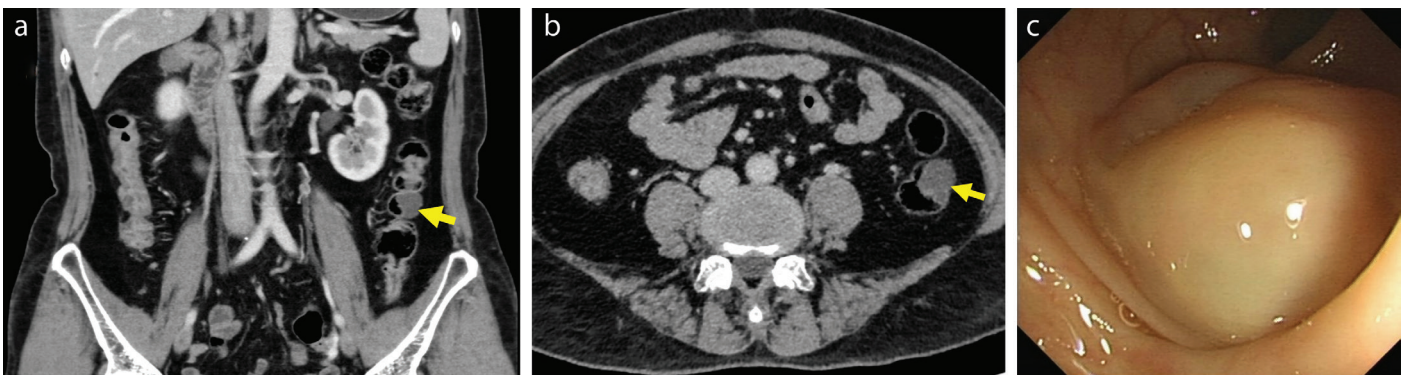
CT and endoscopy findings. a) Coronal and (b) axial CT images revealed a cystic lesion (yellow arrow) in the wall of the descending colon; (c) a submucosal eminence in the colon with a smooth and transparent surface
